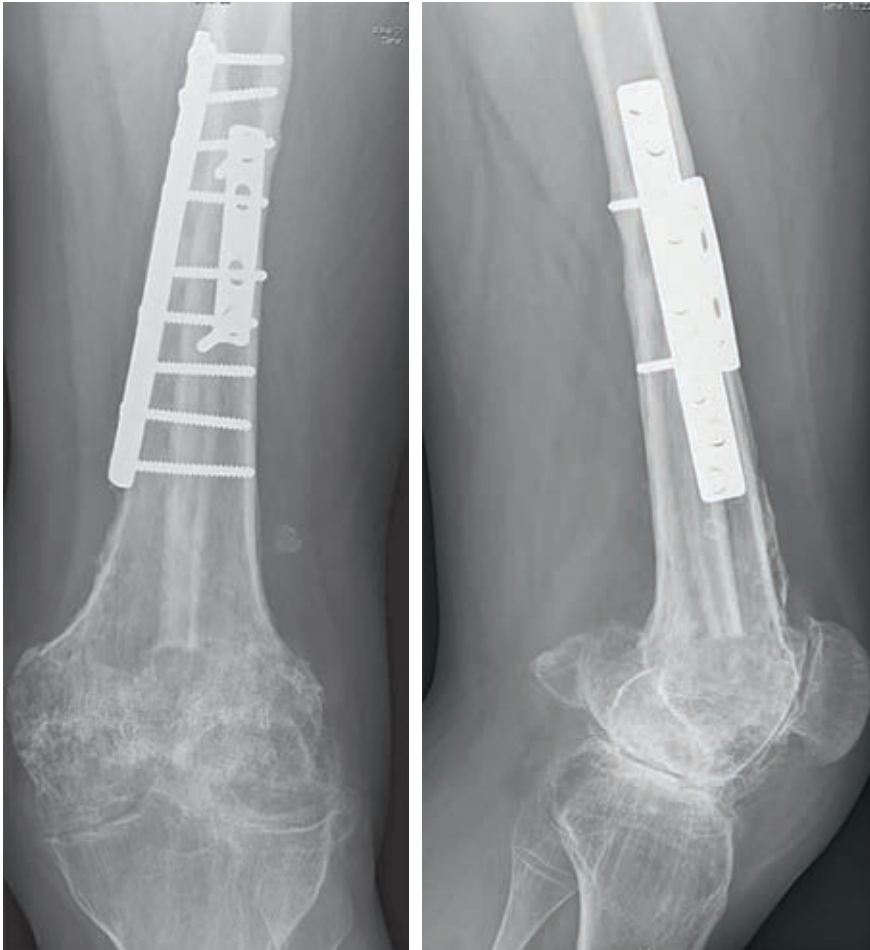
Conventional anteroposterior and lateral radiographs, taken 18 years after a transarticular distal femoral resection for an osteosarcoma in a 14-year-old male patient. The allograft was fixed to host bone using two plates. There is sound incorporation of the allograft. Signs of severe secondary osteoarthritis can easily be identified in the tibiofemoral and patellofemoral joints. The patient was free of pain.
